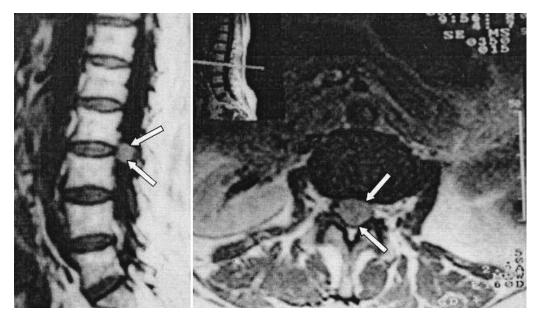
Magnetic resonance imaging (MRI) of the lumbosacral spine. The sagittal (left) and axial (right) views demonstrate a calcified and high signal intensity intradural mass (arrows) at the level of the L1-2, which obliterated the spinal canal
